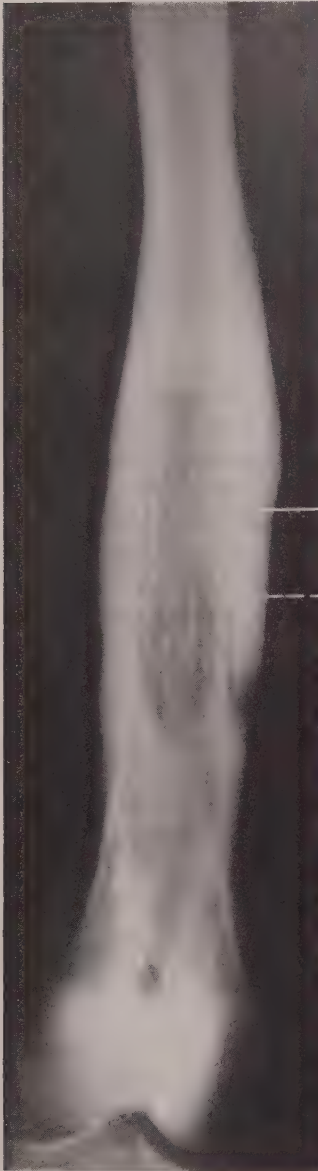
X-ray of femur affected by chronic osteomyelitis, Involucrum shown by continuous line. Sequestrum shown by dotted line.
